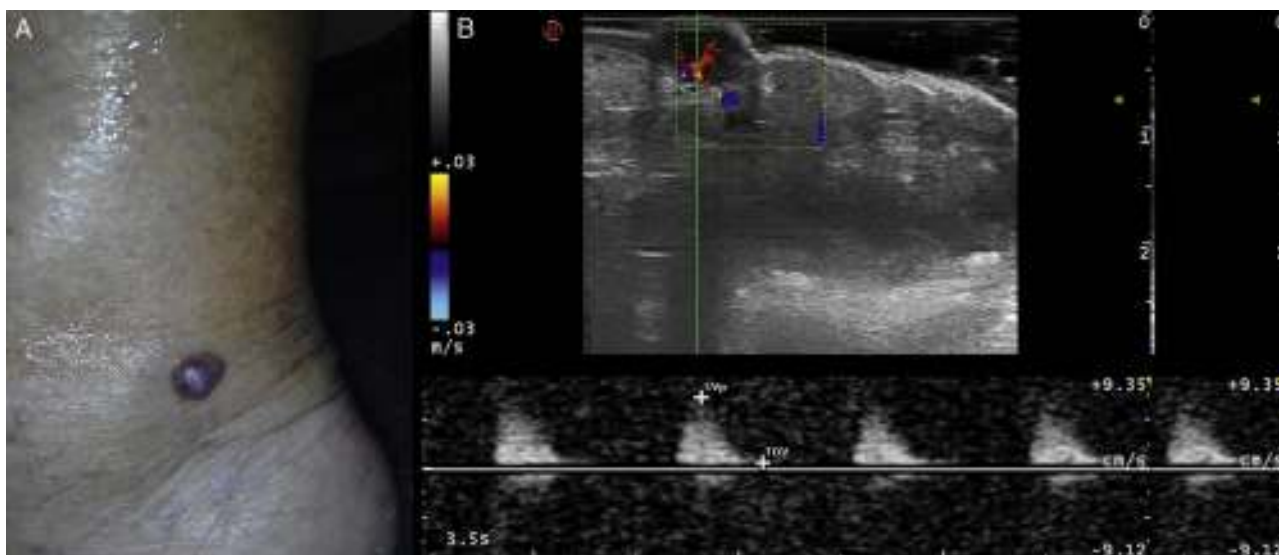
A, Reddish-violaceous nodule on the right ankle. B, The ultrasound lesion shows a solid, hypoechoic, homogeneous oval lesion with regular, well-defined edges in the papillary and reticular dermis. Color Doppler shows intense intralesional vascularization that is more marked in the inferior pole. Biphasic arterial flow is observed in spectral mode.
